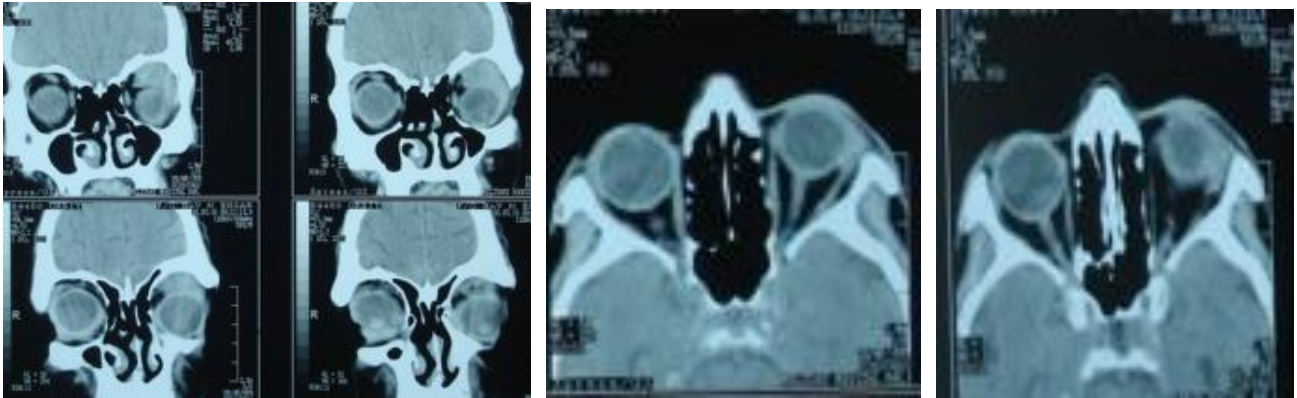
CT scan Left: Coronal view, Right: Axial view. Concavo convex soft tissue density mass, almost homogenous was noted in the left orbit supero laterally.
